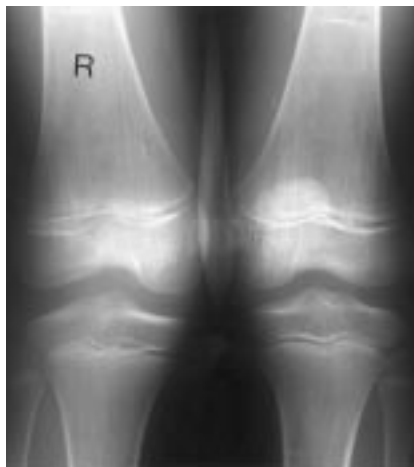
Plain radiograph of a young patient with typical snapping knee syndrome of the right knee demonstrates widening of the lateral joint space and hypoplasia of the lateral tibial spine. (Reproduced with permission from Fanton GS, Andrish JT: Meniscofluoresis: An aid in determining the prognosis of meniscal tears. *Cleve Clin Q* 1983;50:379-383.)
